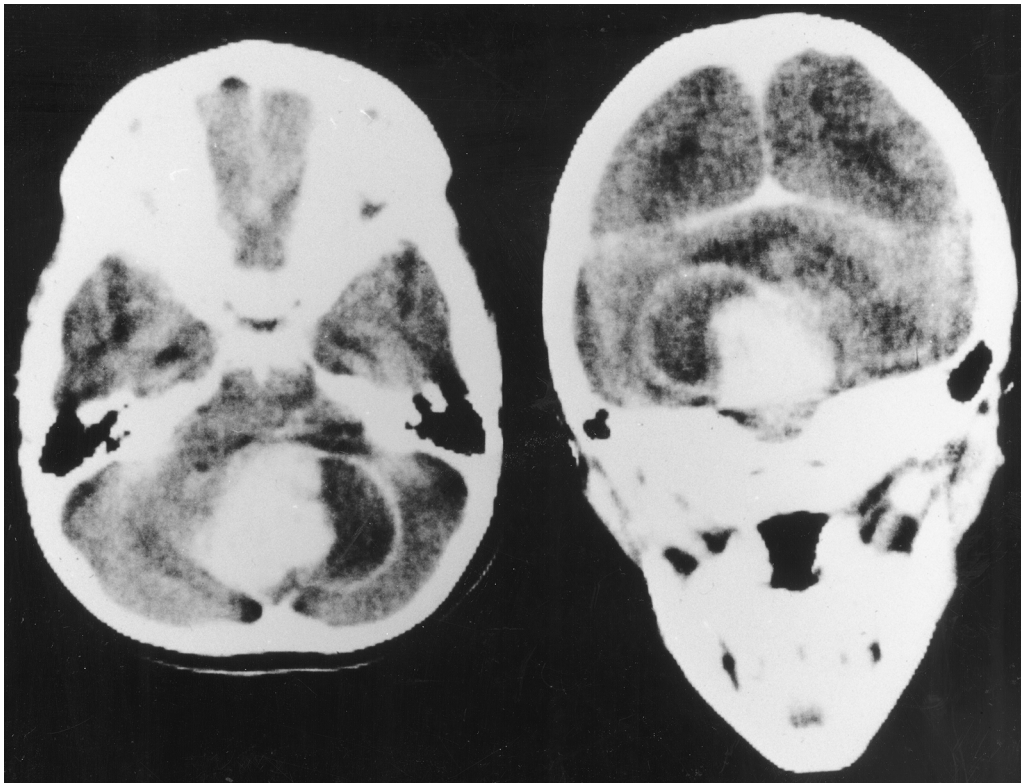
Axial and coronal enhanced CT scans of a child with false cystic cerebellar astrocytoma. Note enhancement of both mural nodule and cyst wall.
